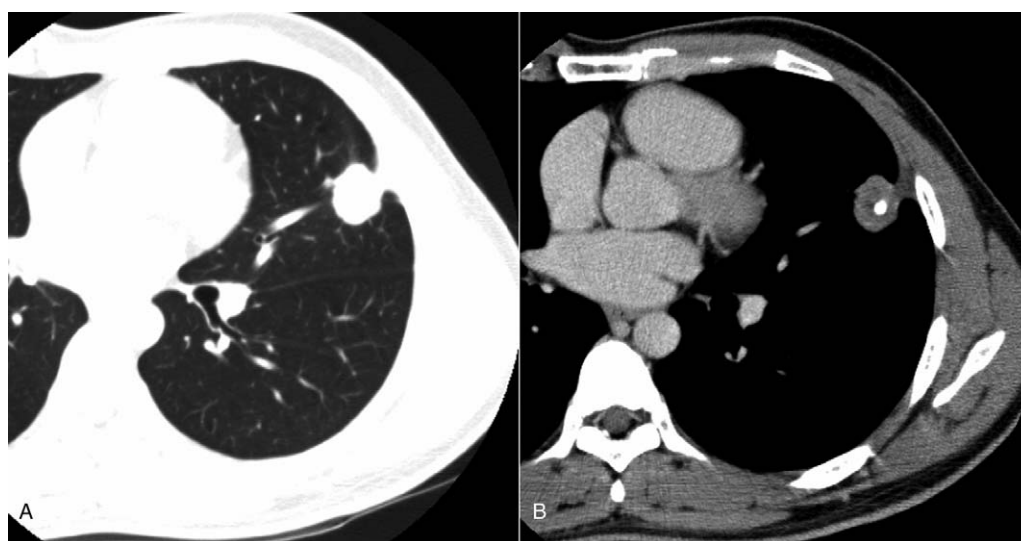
A 25-year-old male presented with a left lung nodule detected by physical examination (subject 6). A, CT shows a nodule in the lingular segment of the left upper lobe with pleural indentation. B, Contrast-enhanced CT shows edge enhancement of the lesion, with nodular calcification, and adjacent local pleura thickening.
